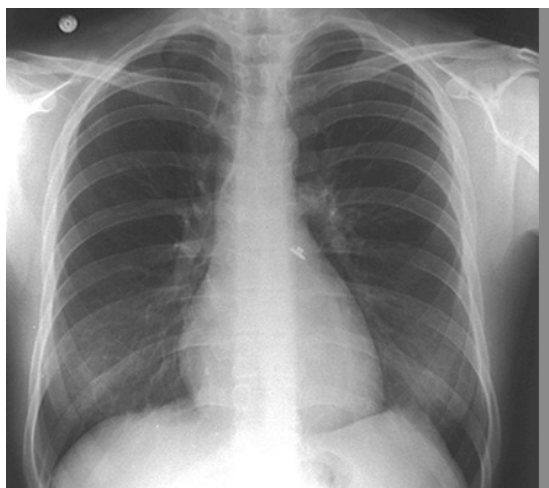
Posterior anterior view of a normal Chest Xray
